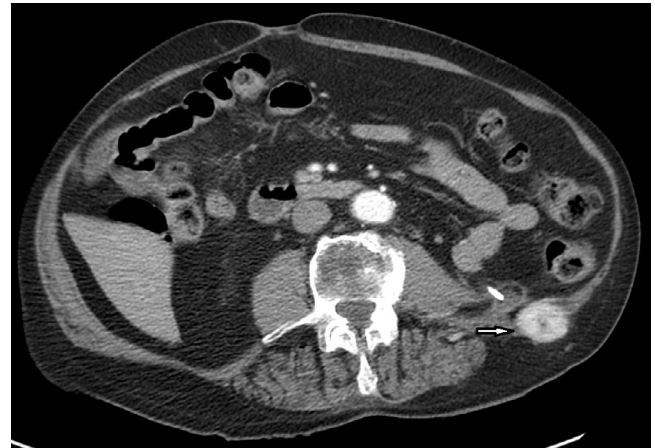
■ Local recurrence of renal cell carcinoma. Post-contrast axial CT performed 5 years after radical nephrectomy demonstrates a focal enhancing mass (see arrow) in the posterior abdominal wall. No other metastatic disease was evident. Originally the tumour had been treated with focal percutaneous therapy and the local recurrence was considered to be secondary to this. In view of the solitary nature of the lesion, and absence of metastatic disease, local excision was performed.
